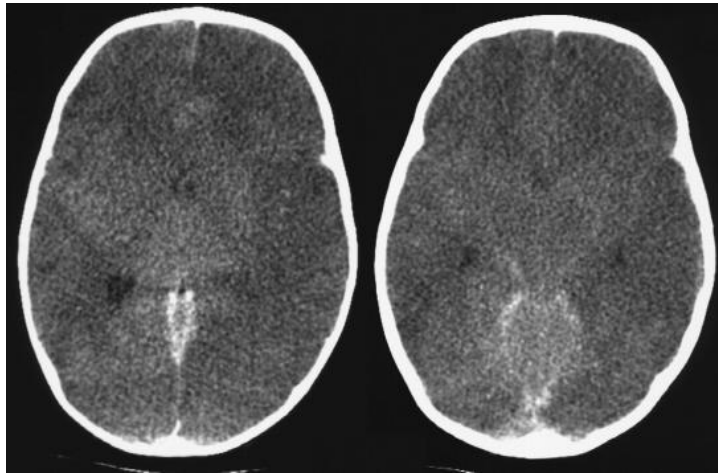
Case 1. Axial nonenhanced CT images through the basal cisterns.
